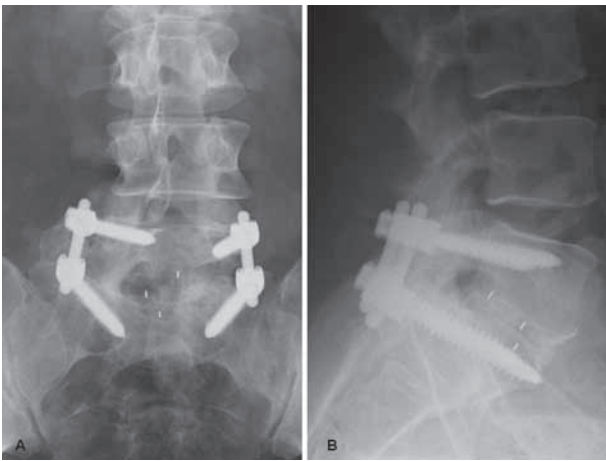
AP (A) and lateral (B) postoperative radiographs 4 years after surgery, showing anatomically aligned lumbo-sacral junction, maintenance of anterior column height, and complete fusion at L5S1 motion segment.
